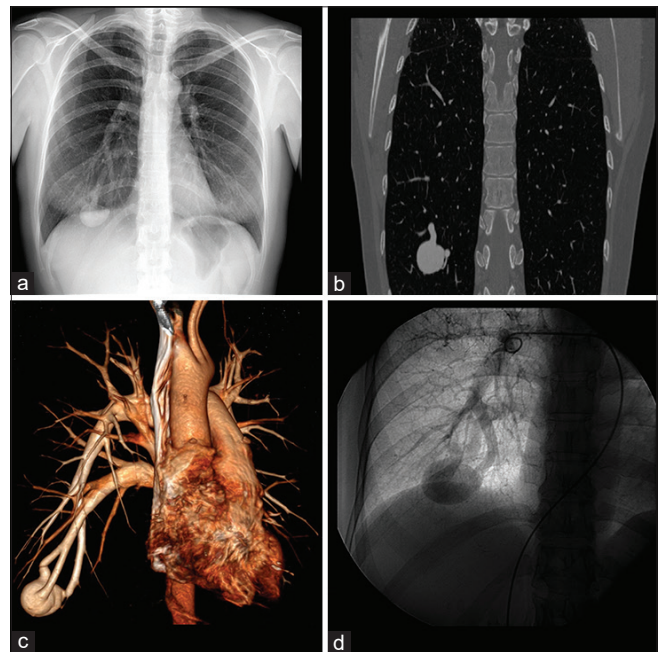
Right lower lobe pulmonary arteriovenous malformations as depicted at (a) chest X-rays; (b) chest angio-computerized tomography on coronal slices and (c) three-dimensional reconstruction; (d) pulmonary angiography
